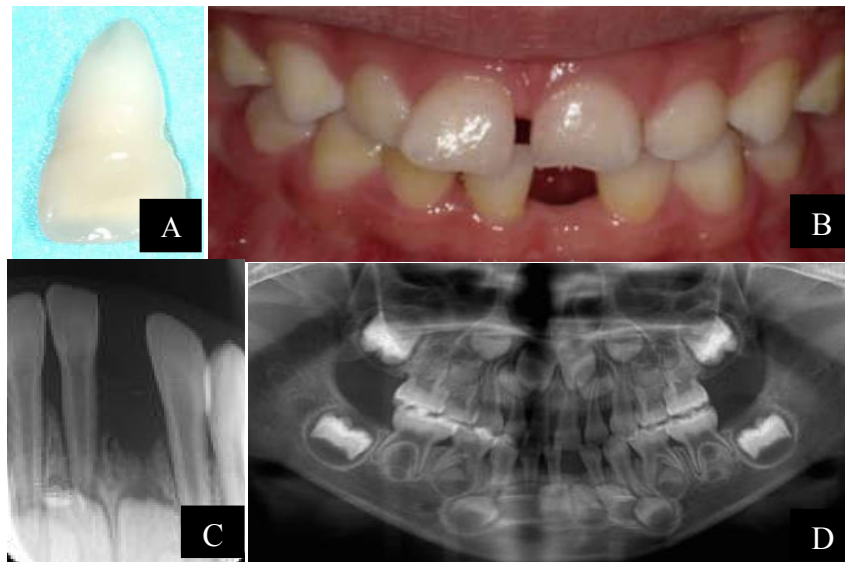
Photograph and X-ray of Case 2: This is a girl aged 3 years and 3 months who has HPP (34). A: Photograph of the exfoliated tooth showing an intact root. B: Photograph of the oral cavity of the child who has lost 71. C: Panoramic X-ray showing a reduced level of the alveolar bone. D: A retro-alveolar of the mandibular incisors showing a reduced bone level
